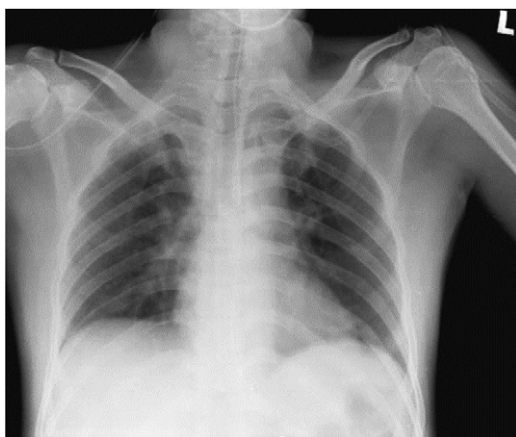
Chest X-ray image on day of admission.
